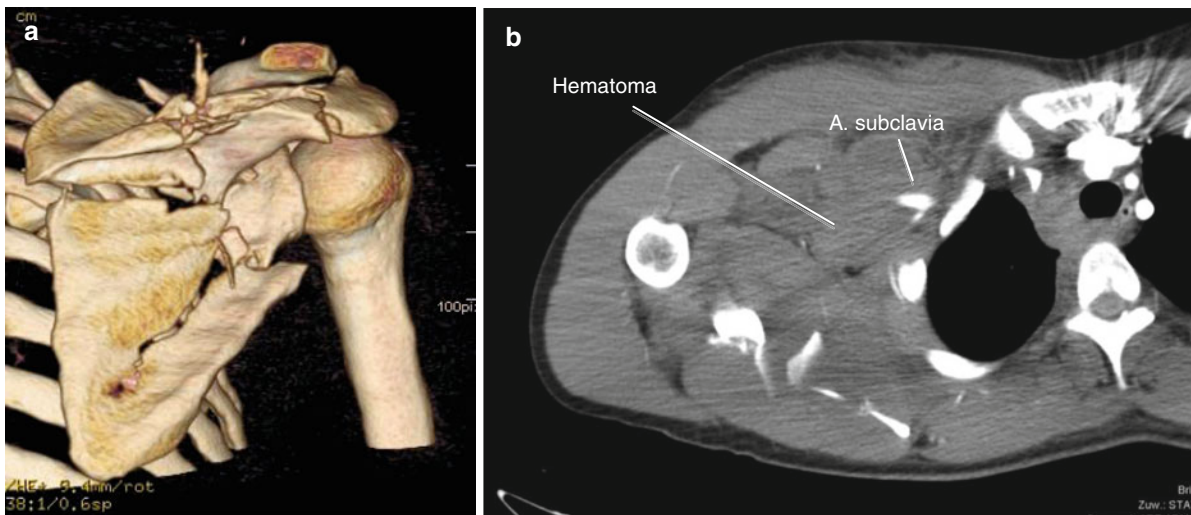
Three-dimensional reconstruction of the computed tomography of a dislocated and unstable fracture of the scapula (a) as the gold standard in the diagnosis of scapular fractures. In
